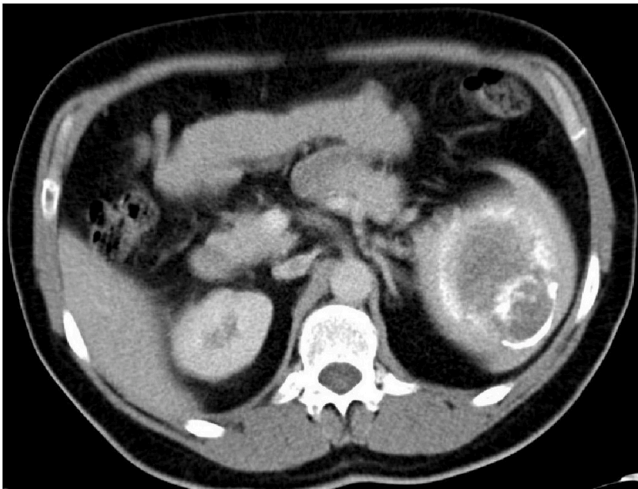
CT slice of the second smaller lesion that was more heterogenous.
